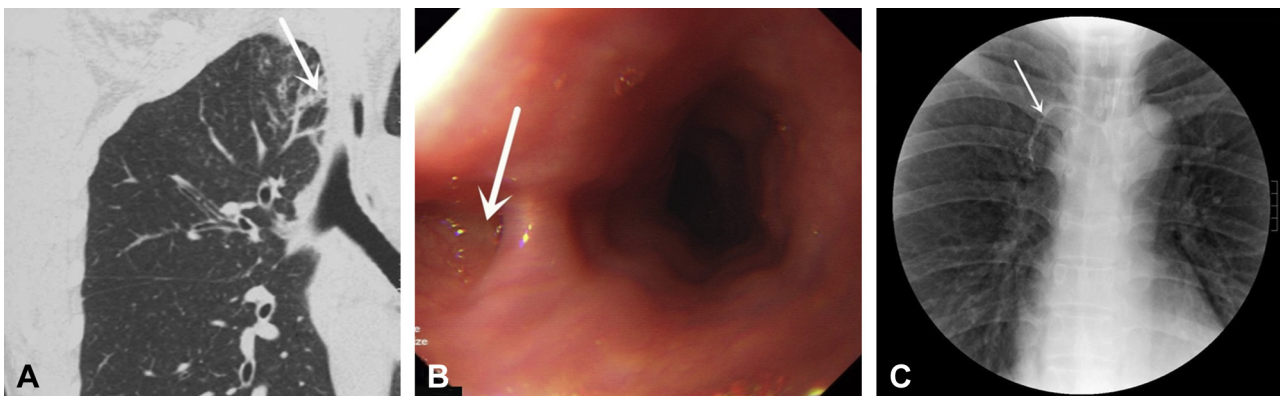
Preoperative examinations. A, Pulmonary CT view showing a tracheoesophageal fistula in the right upper-lobe apex. B, Esophagoscopy view showing a diverticulum at the right wall of the esophagus (23 cm lateral to the mouth). C, Contrast esophagography demonstrating a tracheoesophageal fistula.
